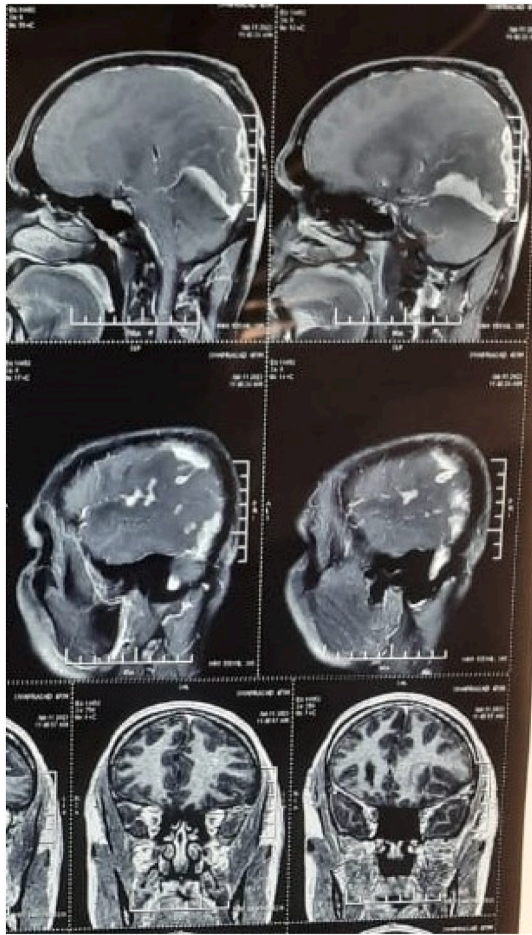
are the magnetic resonance imaging of the brain showing an irregular ill-defined lesion involving the temporoparietooccipital lesion involving the tentorium cerebelli and dura with significant mass effect and edema.
